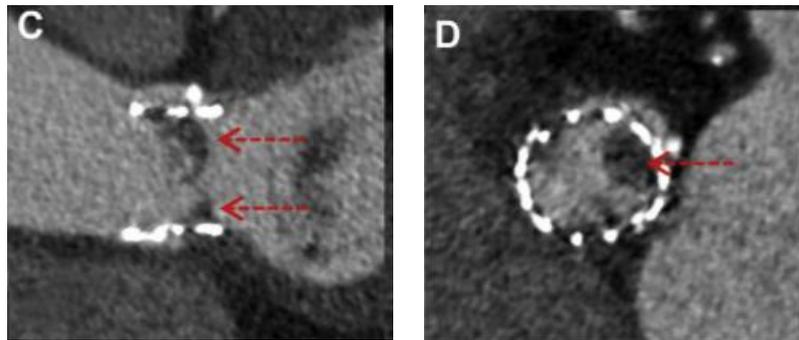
Post-TAVR CT in an 89-year-old male with a SAPIEN 3 prosthesis one year after procedure. Red arrows show presence of leaflet thrombosis.
